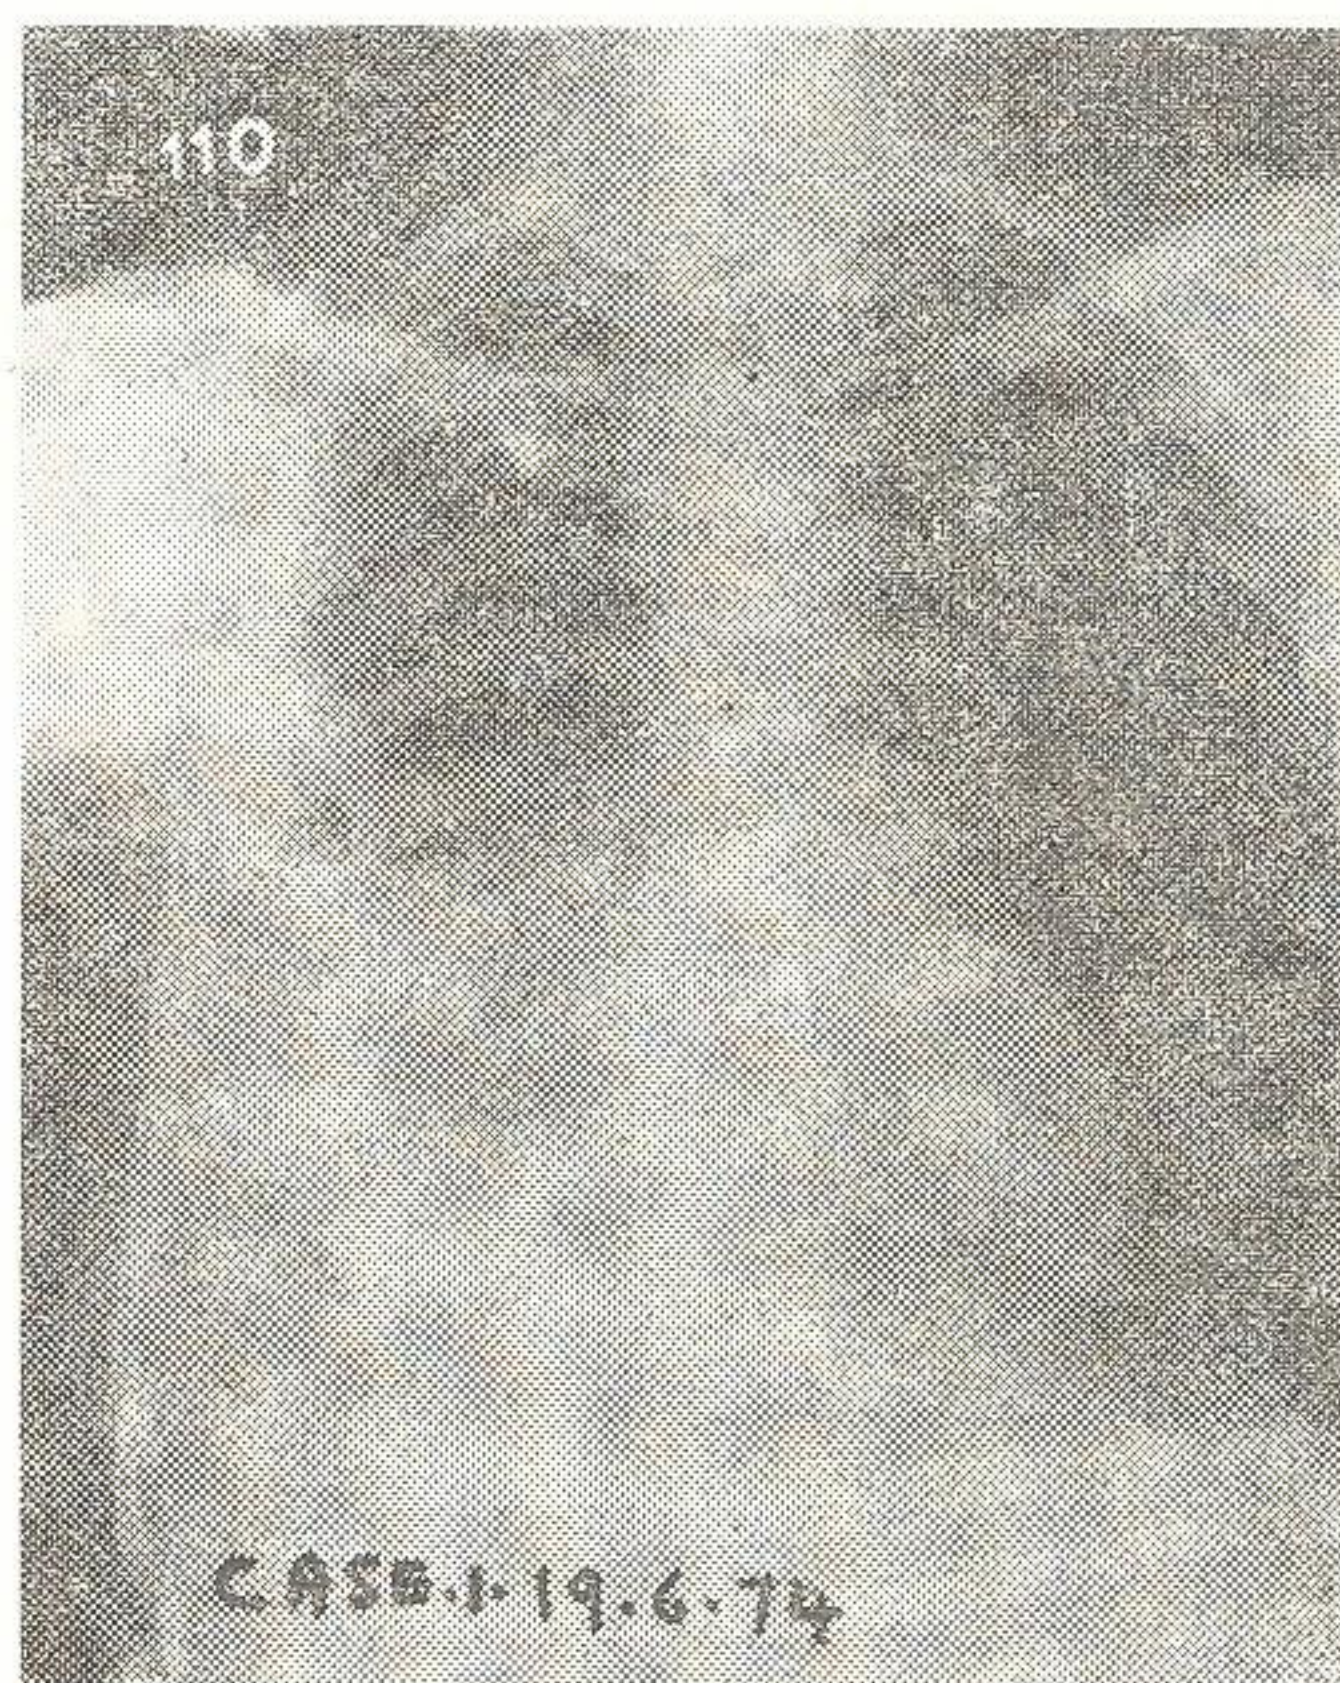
Case-1 (19-6-1978). X-Ray chest after drainage of empyema with drainage tube. The empyema is lessened with localised abscesses at the drainage points.
